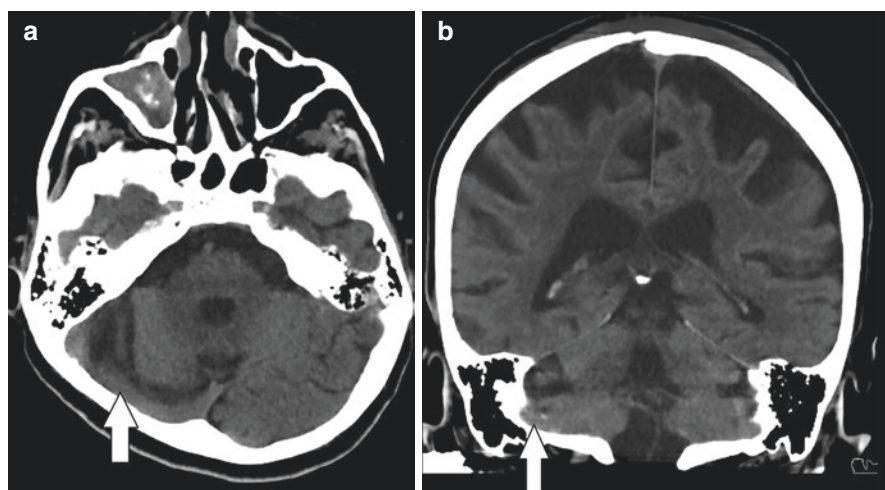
In the case with increased CSF gaps secondary to cerebral atrophy, axial brain CT (a) right transverse sinus, coronal image (b) sigmoid sinus is observed as hyperdense due to slow flow
